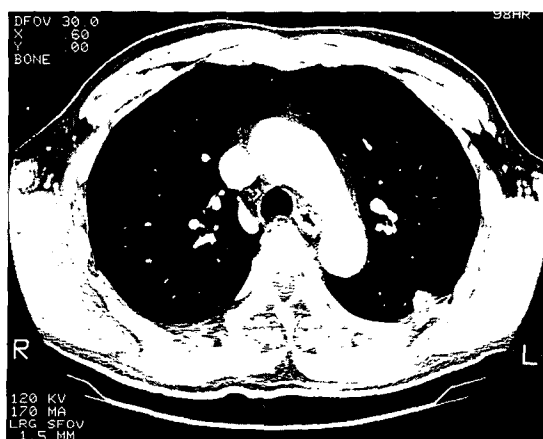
Computed tomographic scan of the lung showing an about 1cm-sized subpleural nodule in left lower lung field(arrow).
